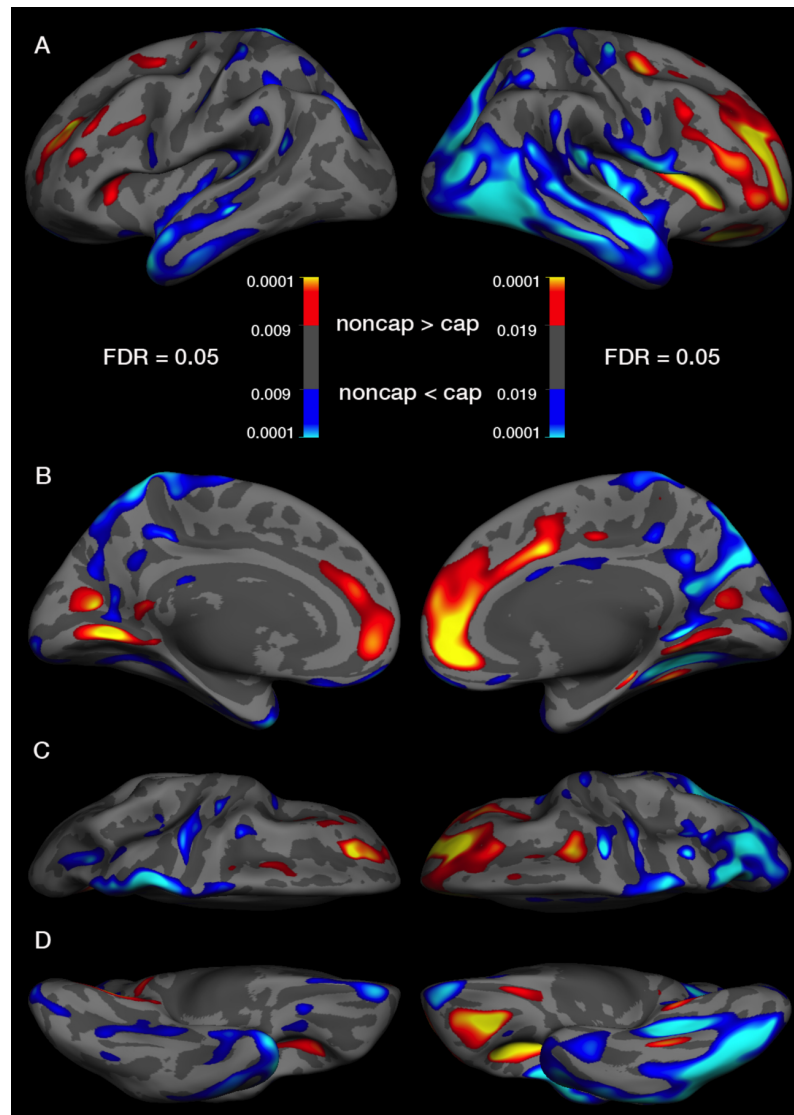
The influence of the high-density EEG net on cortical surface area measurement derived from surface-based morphometry of T1-weighted images shown on A) lateral, B) medial, C) superior, and D) inferior view of the left (left column) and right (right column) hemisphere. Blue indicates an increased and yellow-red a decreased cortical surface area when subjects do wear the EEG cap in the scanner (paired t -test, FDR = 0.05 false discovery rate corrected). The color bar represents FDR corrected p-values.
